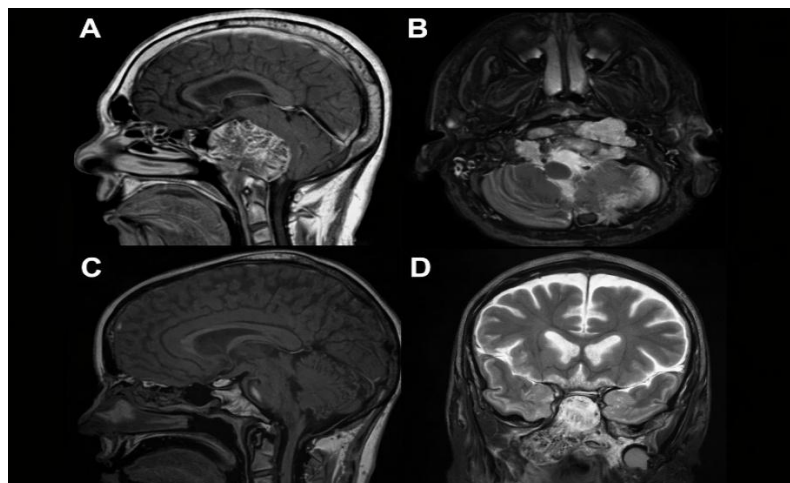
Chordomas of The Base of The Skull Can Invade Different Anatomical Compartments. A Gadolinium-Enhanced MRI Sagittal T1 Reveals a Large Chordoma, Mostly Containing the Upper and Lower Clivuses. B Tumor Squeezing the Brain Stem and Infiltrating the Occipital Condyles Is Visible on The MRI Axial T2 Scan. C MRI Sagittal T2; The Tumor Is Encroaching on C2 And Other Lower Craniocervical Junction Compartments. D MRI Coronal T2: Massive Tumor Encroaching on Extracranial Spaces(Shimony et al., 2017).
